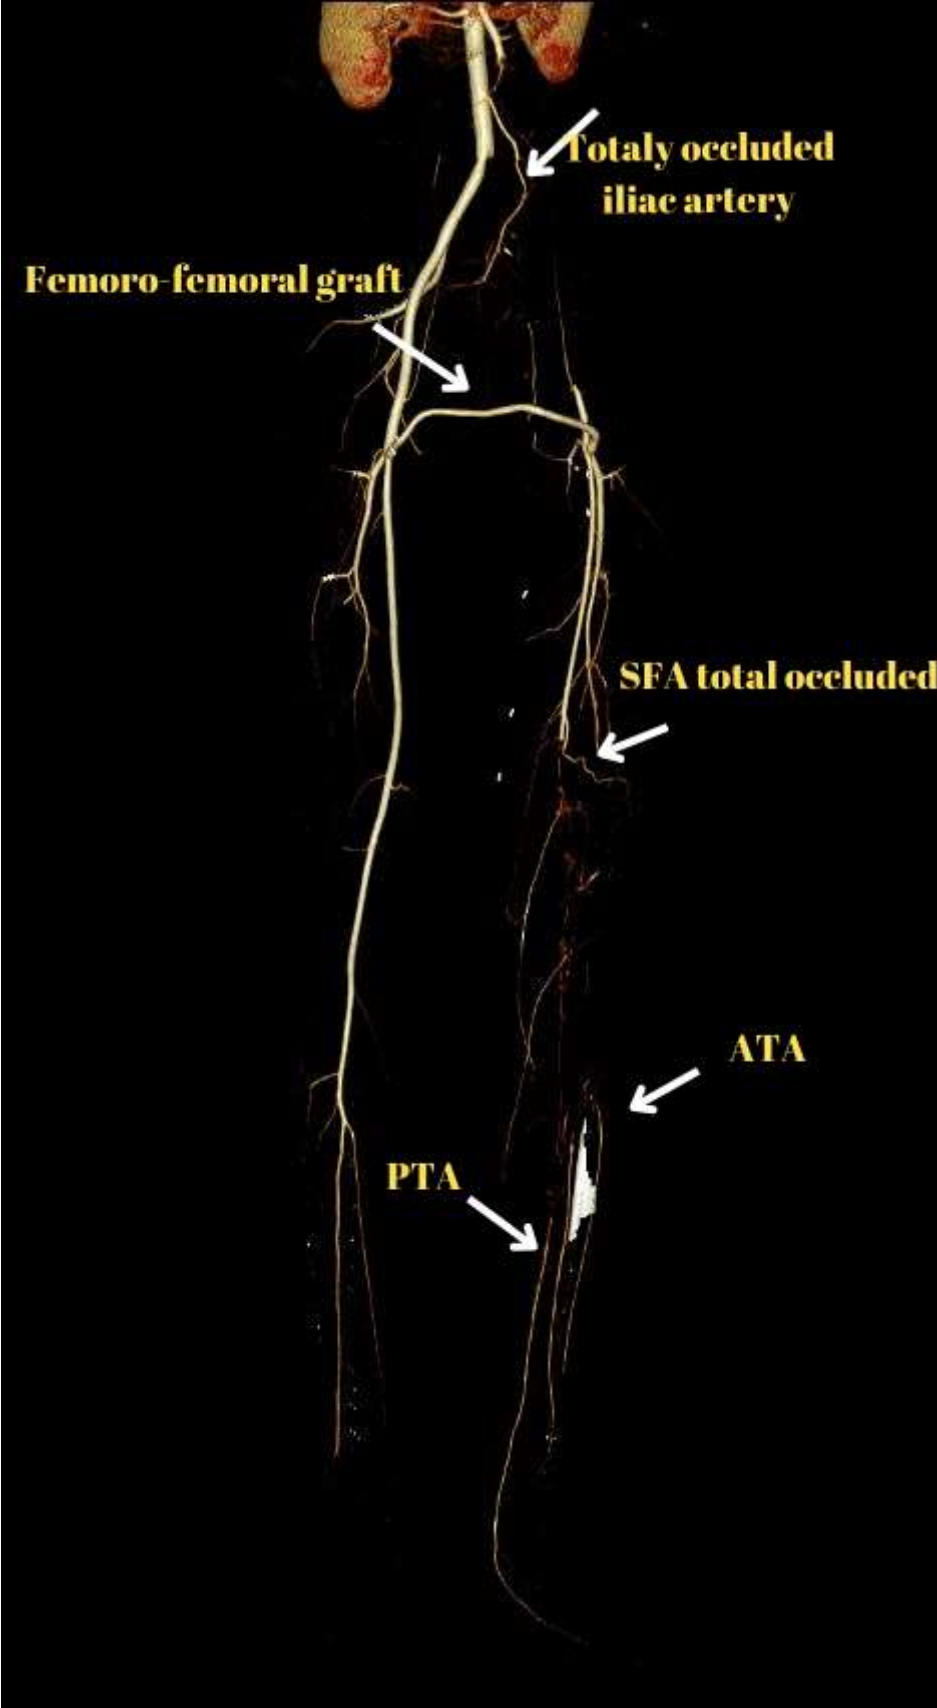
Lower extremity computed tomography angiography, 3D reconstruction
